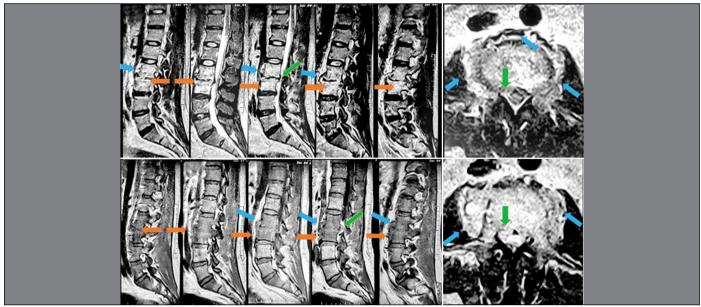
MRI showing degeneration of the L2-L3, L3-L4, L4-L5, and L5-S1 intervertebral discs, a protruded L2-L3 herniation, L3-L4 spondylodiscitis (orange arrows), an epidural abscess (green arrows) compressing the dural sac, and lateral and anterior paravertebral abscesses (green arrows).
